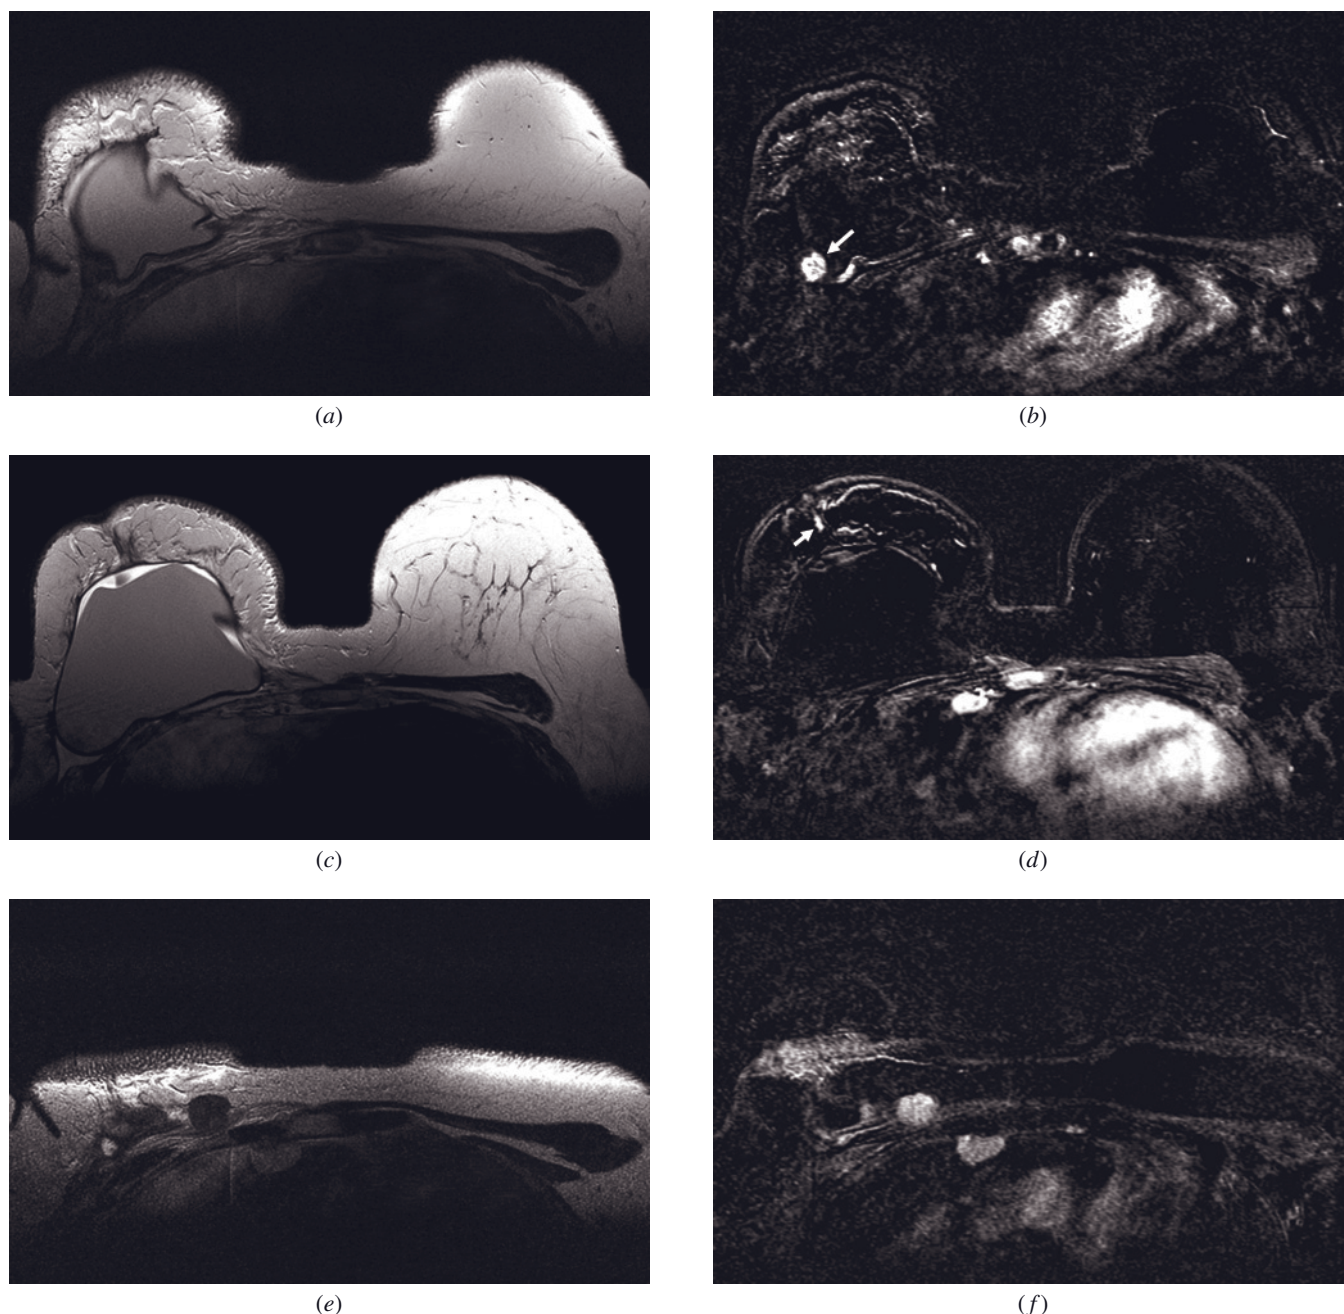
MRI of the breast after subcutaneous mastectomy with silicone implant endoprosthesis in right breast. Axial T2-weighted image (*a*) shows hypointense lesion lateral to the implant with strong postcontrast enhancement on subtracted image (arrow, *b*) corresponding to tumor recurrence. In the subareolar region, DCIS is seen as clumped, ductal enhancement on subtracted (arrow, *d*) image, while T2-weighted image (*c*) was negative. In addition, enlarged ipsilateral infraclavicular and parasternal lymph nodes are seen (*d-f*). MRI is considered the most sensitive and reliable imaging modality for local assessment after breast cancer treatment. Note the nonuniform fat suppression of the right breast (*c*), a frequent but not diagnostically disturbing observation.
